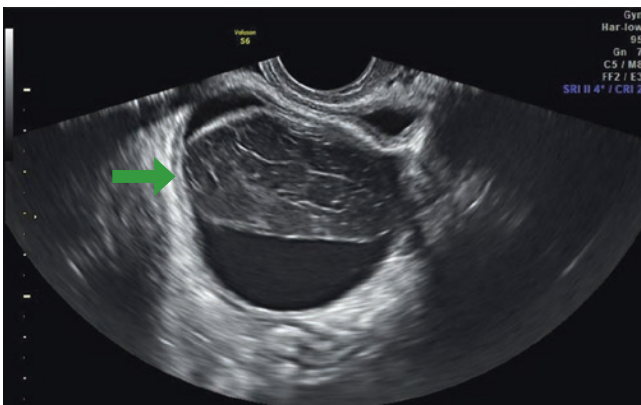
Hemorrhagic cyst of the right ovary. Transverse endovaginal sonogram reveals fibrinous strands (*arrow*) and low-level internal echoes
